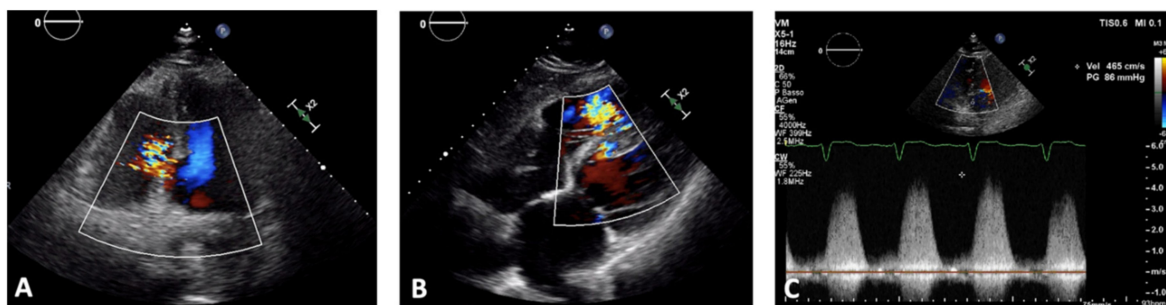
Ventricular septal defect (VSD) in a patient diagnosed with subacute myocardial infarction 3 days after reperfusion of right coronary artery. (A) Apical four-chamber view shows presence of a posterior VSD. Color Doppler mode demonstrated a high-velocity flow through the neck of the VSD, which corresponds to left-to-right shunt. (B) Subcostal view confirmed presence of a serpiginous posterior VSD with left-to-right shunt. (C) Continuous-wave Doppler imaging showed presence of a high velocity shunt, although underestimated because of non-completely parallel positioning of doppler-marker as respect to flow direction.
